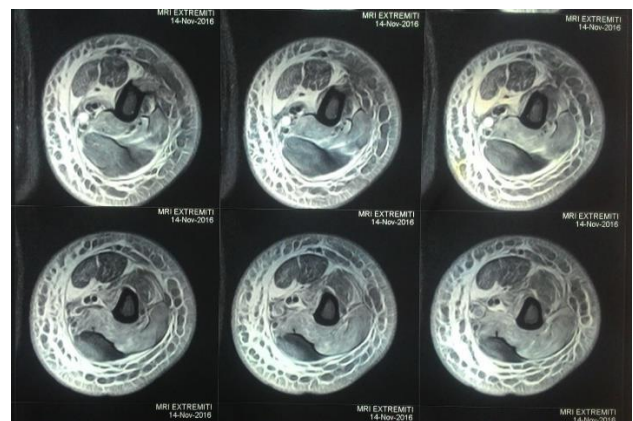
MRI of left upper arm.
